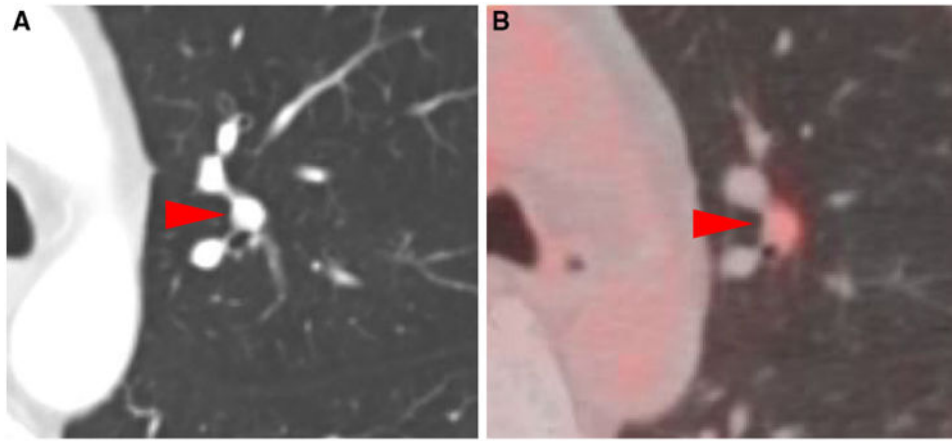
Subtle radiotracer uptake (SUV_{max} 1.7) in a small lung nodule (1 cm in diameter) as seen on contrast-enhanced CT (a) and ^{18}F -DCFPyL PET/CT (b) (*arrowheads*) in patient #2
